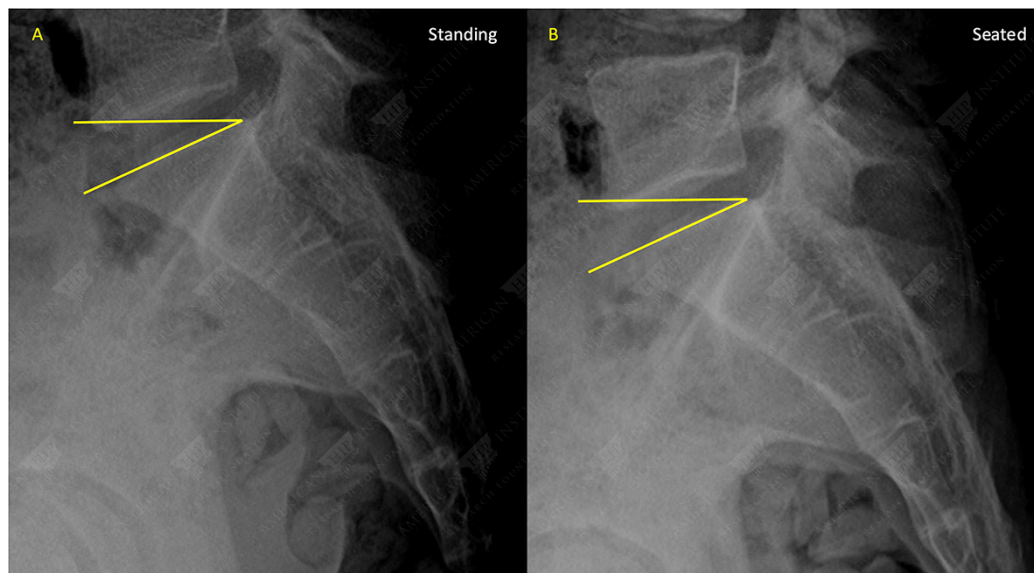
Sacral slope measurements (yellow lines) on standing (A) and seated (B) x-rays.
